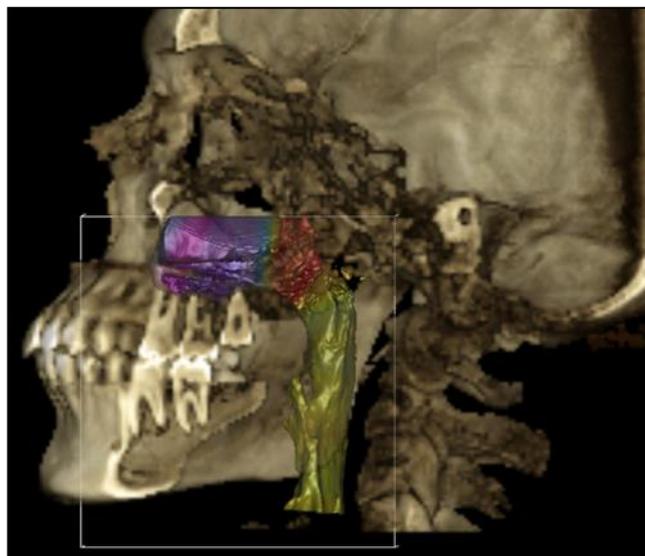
Semi-automated segmentation of upper airway in a 3-D reconstructed CBCT. (Software Planmeca Romexis, Version 5.1.0)
